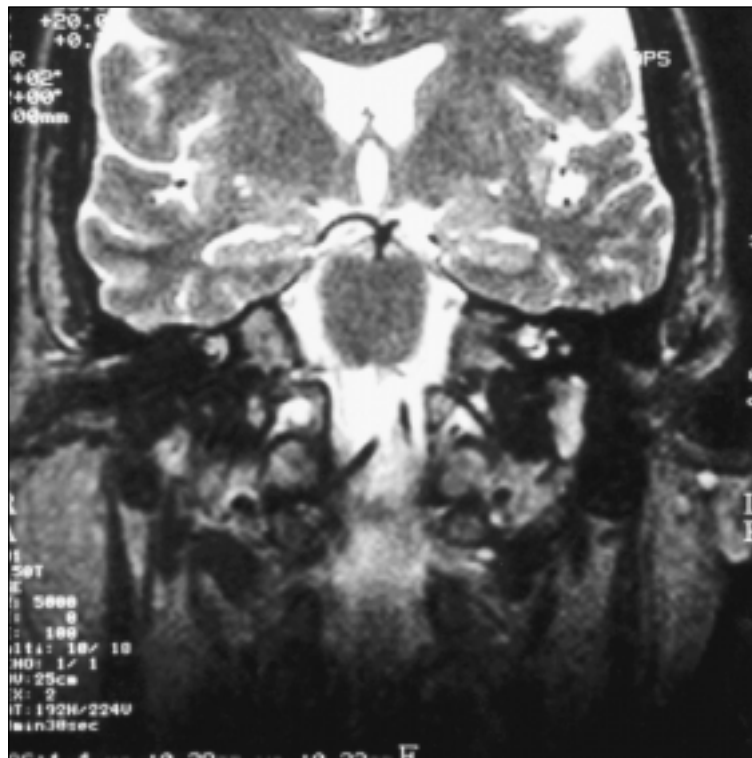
Coronal MRI scan showing an hyperintense and homogeneous mass affecting the mastoid segment of the FN. The diagnosis of FN shwannoma was suggested preoperatively.
